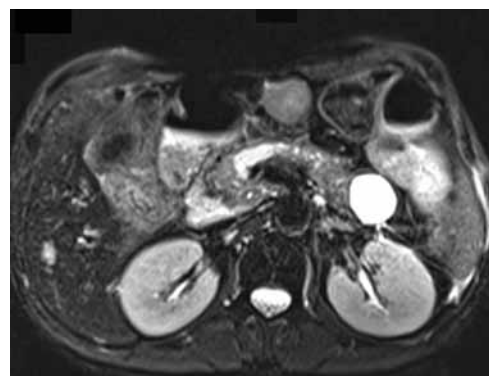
Upper abdomen MRI: tumor at the head of the pancreas.
